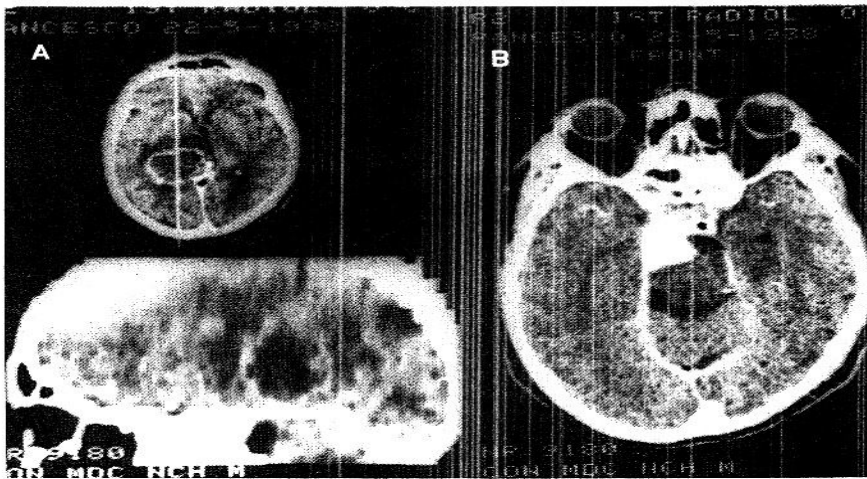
Contrast enhanced CT scan showing: A) an irregularly ring-shaped hypodense lesion situated in the left posterior paraventricular region; B) hyperdense homogeneously enhancing retrosellar mass extending to the left cavernous sinus
